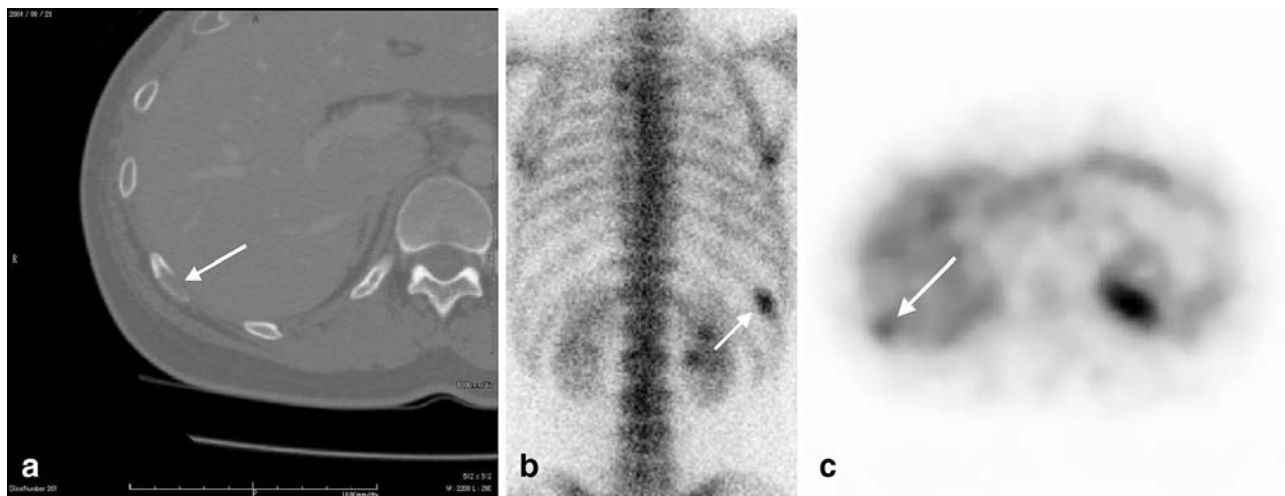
a Axial CT image of a lytic-type metastasis in a 75-year-old man with breast carcinoma. A lytic metastasis is visible in the right 10th rib (*arrow*). b Posterior bone scintigram. The 10th rib contains a lytic metastasis in the form of a hot lesion (*arrow*), highly suggestive of a metastasis. c Axial FDG-PET image. Uptake was observed in the lytic metastasis to the 10th rib (*arrow*)
